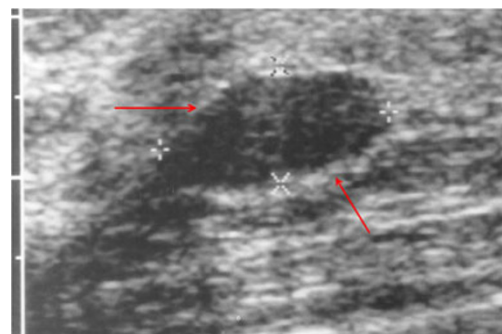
Female patient with CNC. Sonography of the right breast demonstrates a solid, ovoid in shape, well circumscribed, hypoechoic lesion (red arrow). FNA was consistent with myxoid fibroadenoma
